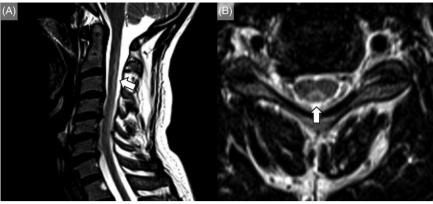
Cervical spinal cord MRI. Sagittal (A) and axial (B) T2-weighted MRI demonstrates a contiguous, non-enhancing, increased signal lesion in the posterior columns between the cervical segments C2–C6 (inverted 'V' sign).
